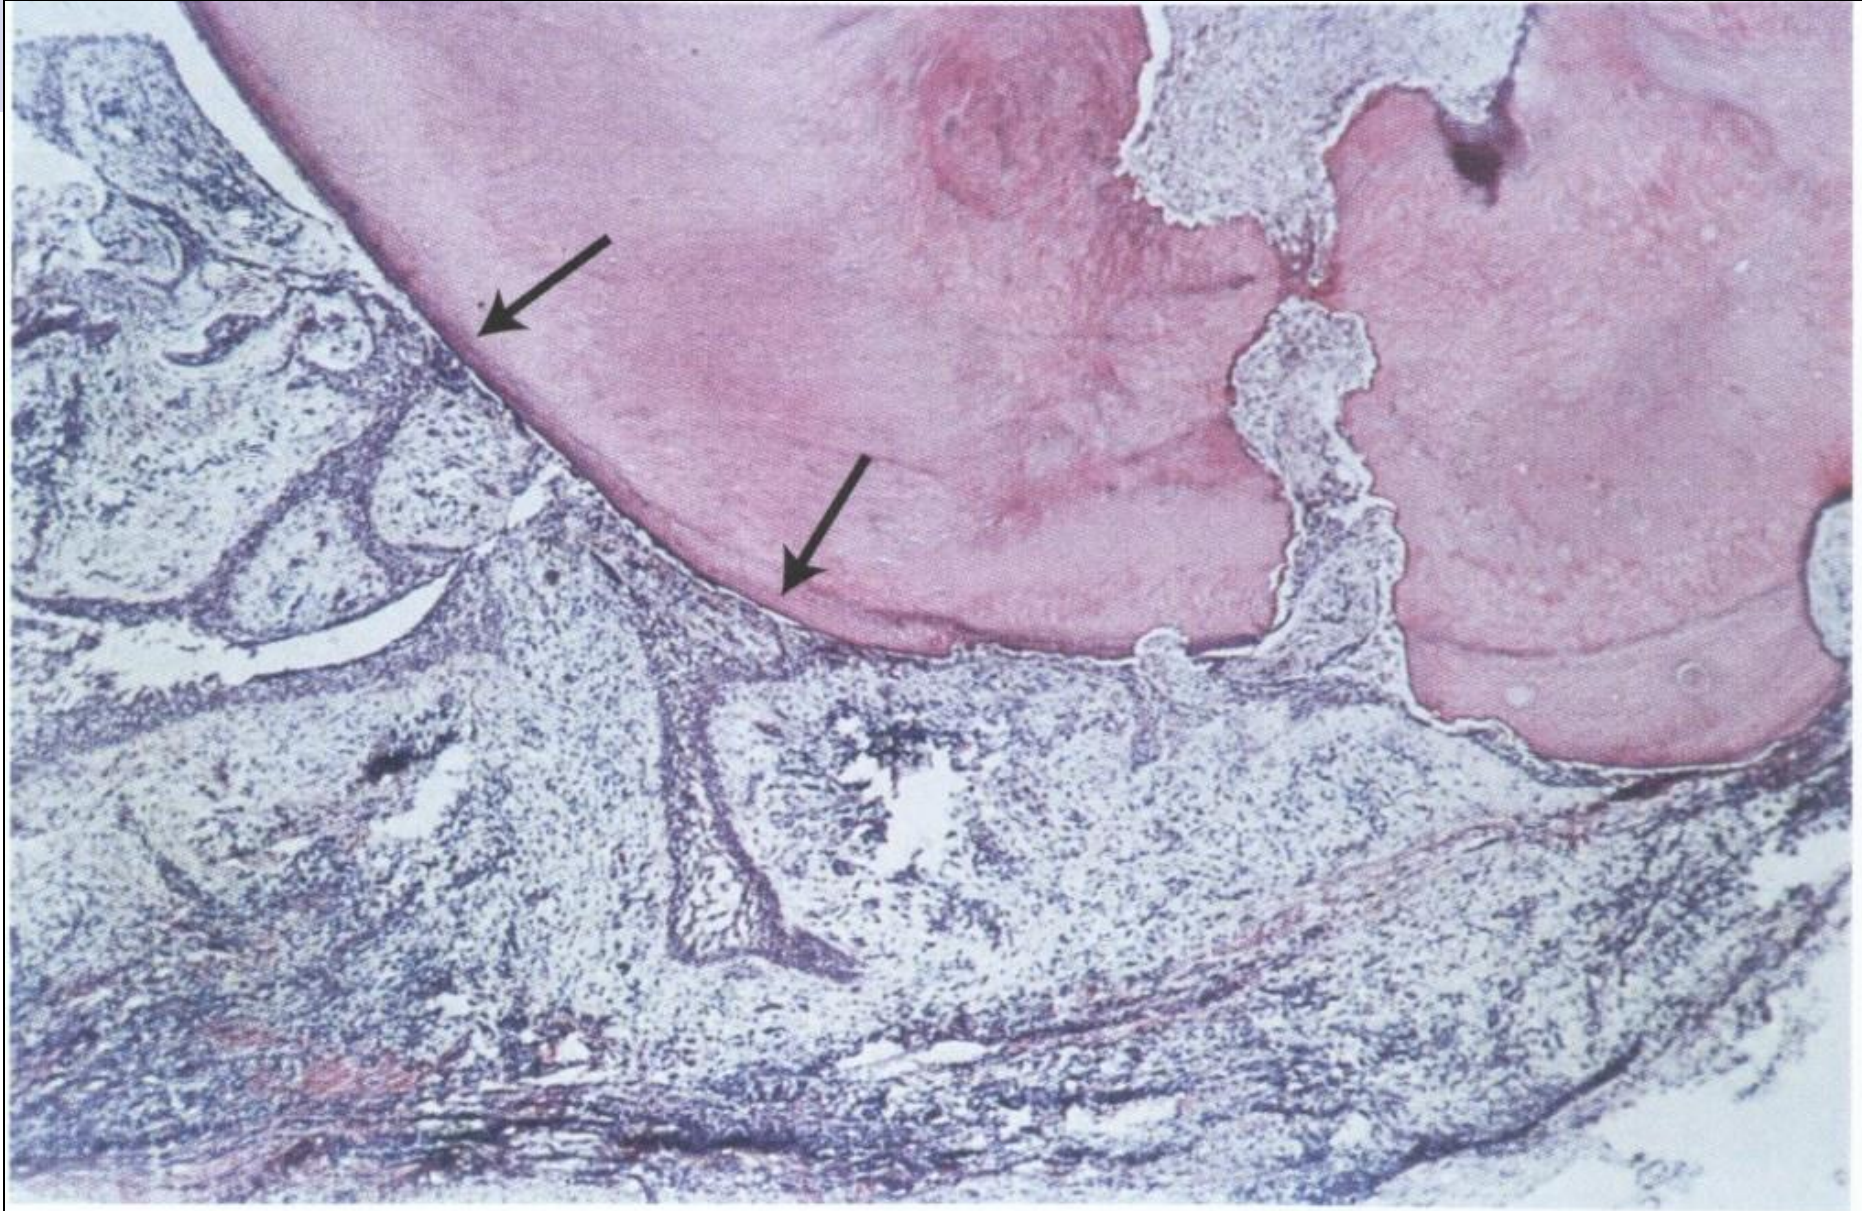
Epithelial strands in a periapical granuloma that seem to attach to the root tip (arrows).
